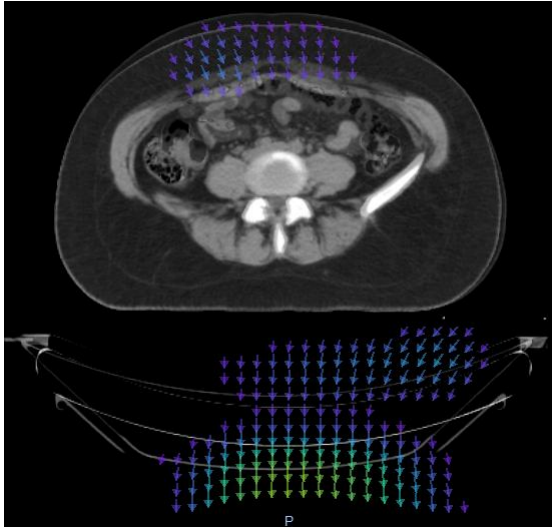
Axial CT image overlaid with the vector map resulting from deformable registration between two CT scans.
